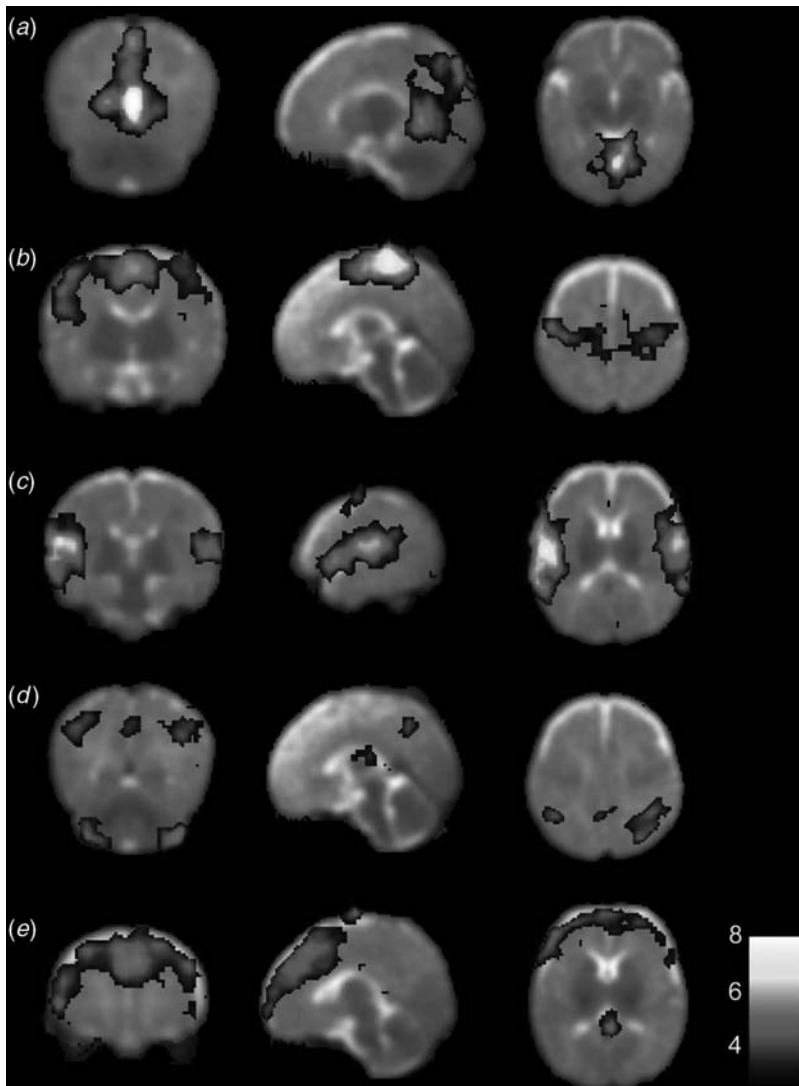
(See color plate section.) Functional magnetic resonance imaging used to map the resting state activity of the brain in lightly sedated infants around term reveals several unique resting-state networks that encompass (a) the primary visual cortex, (b) the somatosensory and motor areas, (c) primary auditory cortex, (d) posterior lateral and midline parts of the parietal lobe and lateral aspects of cerebellum, and (e) the medial and dorsolateral prefrontal cortex, a network potentially of importance for access to consciousness. (From Fransson *et al.*, 2007.)
